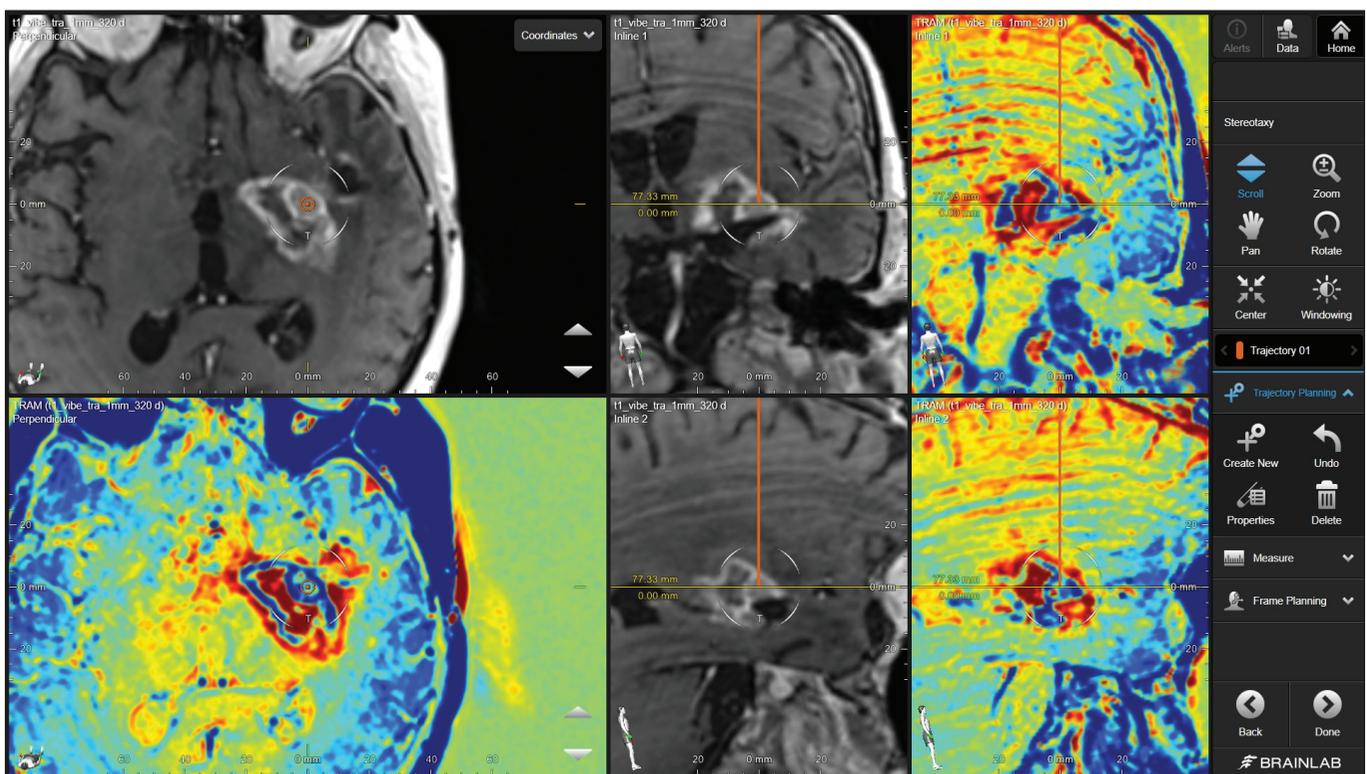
A case of a putaminal mass in a patient with a radiation therapy history for a glial tumor. Contrast-enhanced axial T1-Weighted magnetic resonance images show a heterogeneously enhancing lesion. Color-coded Treatment Response Assessment Maps provided by Contrast Clearance Analysis Module of Brainlab Elements™ (Brainlab AG, Munich, Germany). An anterolaterally located area with a relatively high contrast clearance (depicted in blue) was targeted. A diagnosis of the recurrent tumor was concluded after the biopsy.
